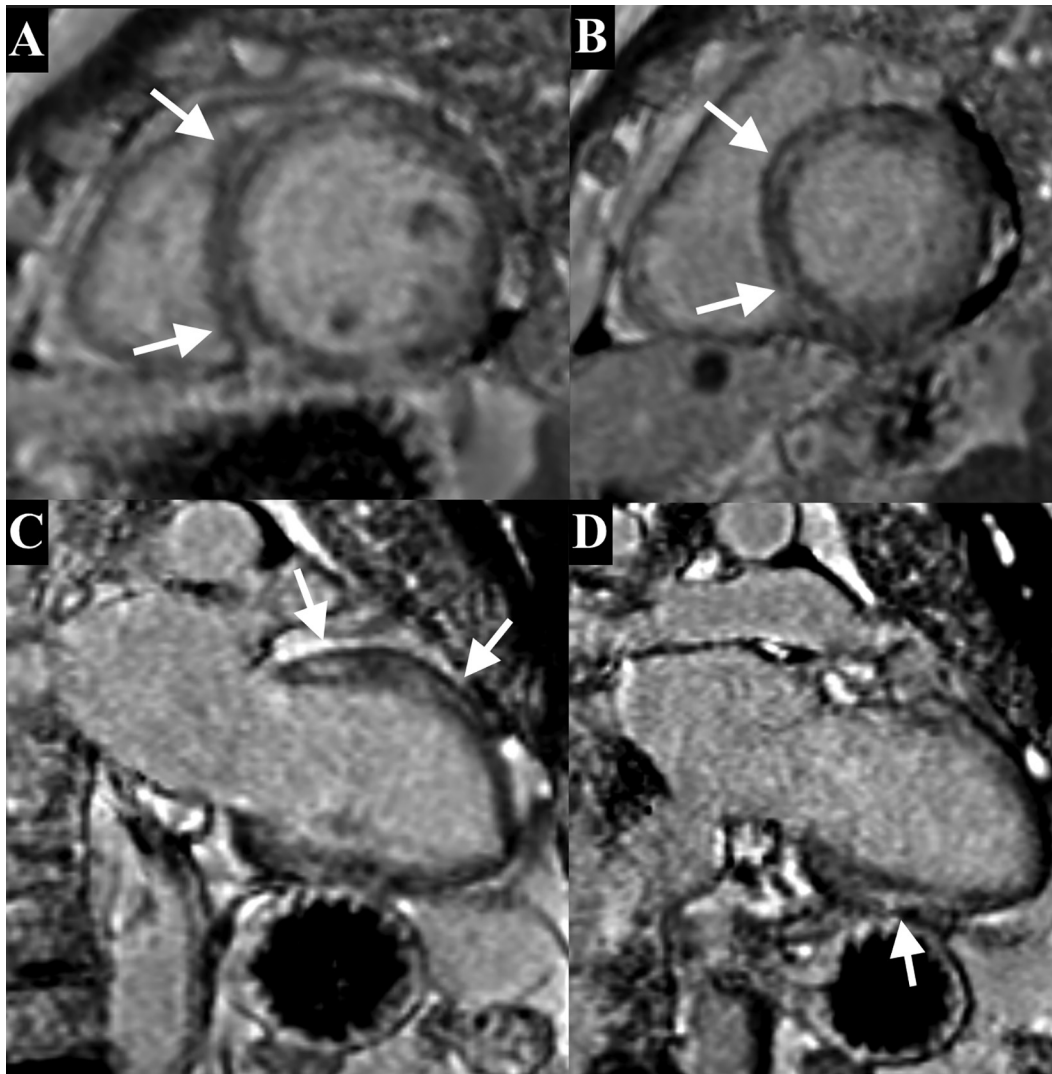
Cardiac MRI of the proband's father. Late gadolinium enhancement in the short-axis view during end-diastolic phase at the mid-ventricular (A) and apical (B) segments of the left ventricle, and in the 2-chamber view (C, D): nonischemic intramural myocardial fibrosis of the left ventricle, displaying a striated pattern in ≥ 1 segment of the LV free wall and interventricular septum. LV = left ventricular, MRI = magnetic resonance imaging.
